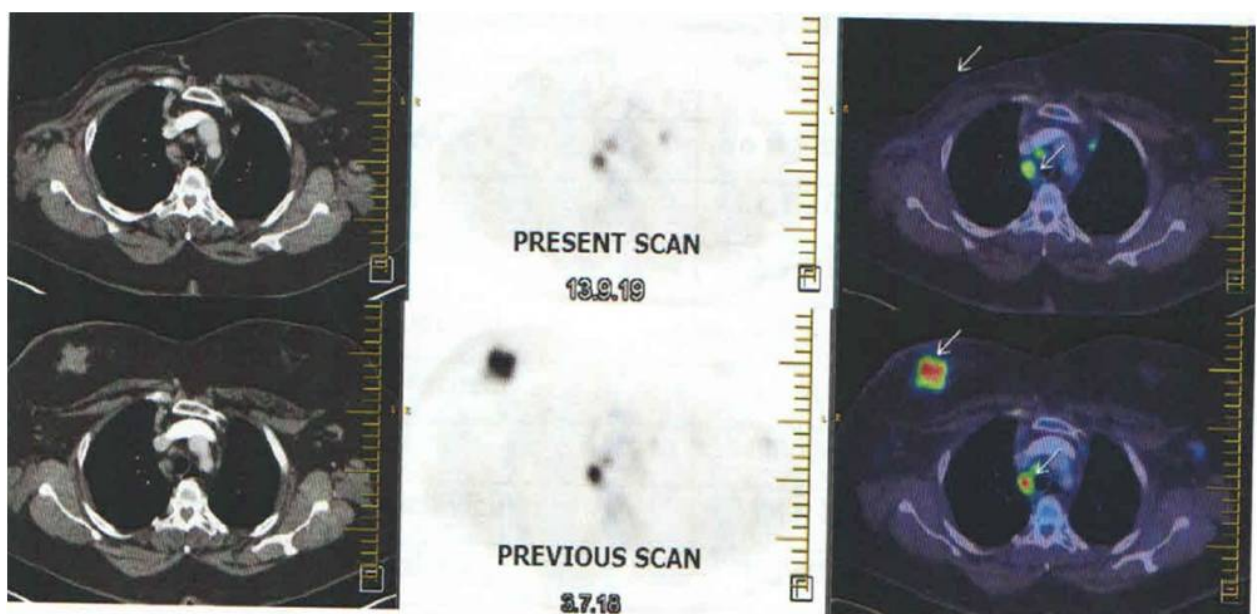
18F-FDG PET/CT scan report showing comparative results of recent and earlier scan of the breasts
